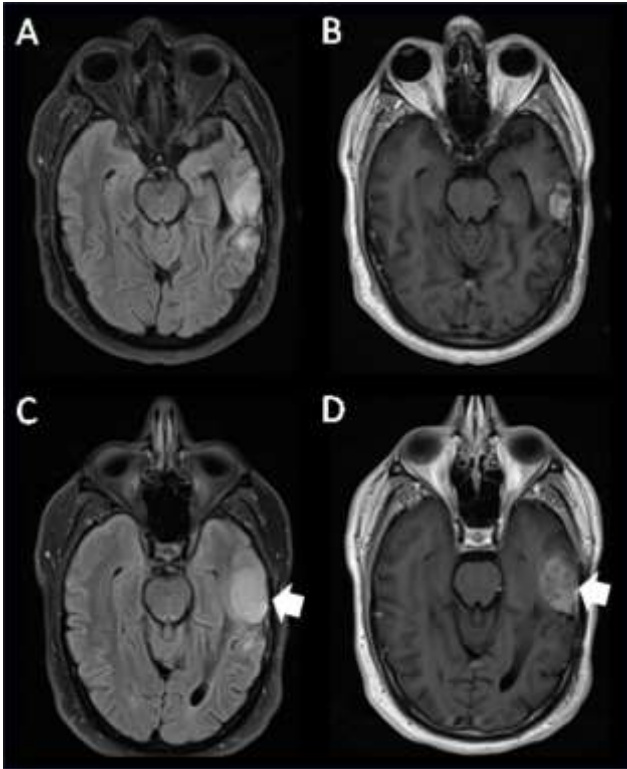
Imaging from a patient with agreement among all readers. 48-year-old man with IDH wild type glioblastoma. FLAIR (A) and T1 post-contrast (B) imaging 18 months after surgery showing abnormal FLAIR and enhancing treated tumor in the left temporal lobe. FLAIR (C) and T1 post-contrast (D) two months later showing marked increase in the size of abnormal mass-like FLAIR and enhancement (white arrows) with $> 25\%$ increase in cross-sectional area. All readers gave the study a score of BT-RADS 4. BT-RADS = brain tumor reporting and data system.
